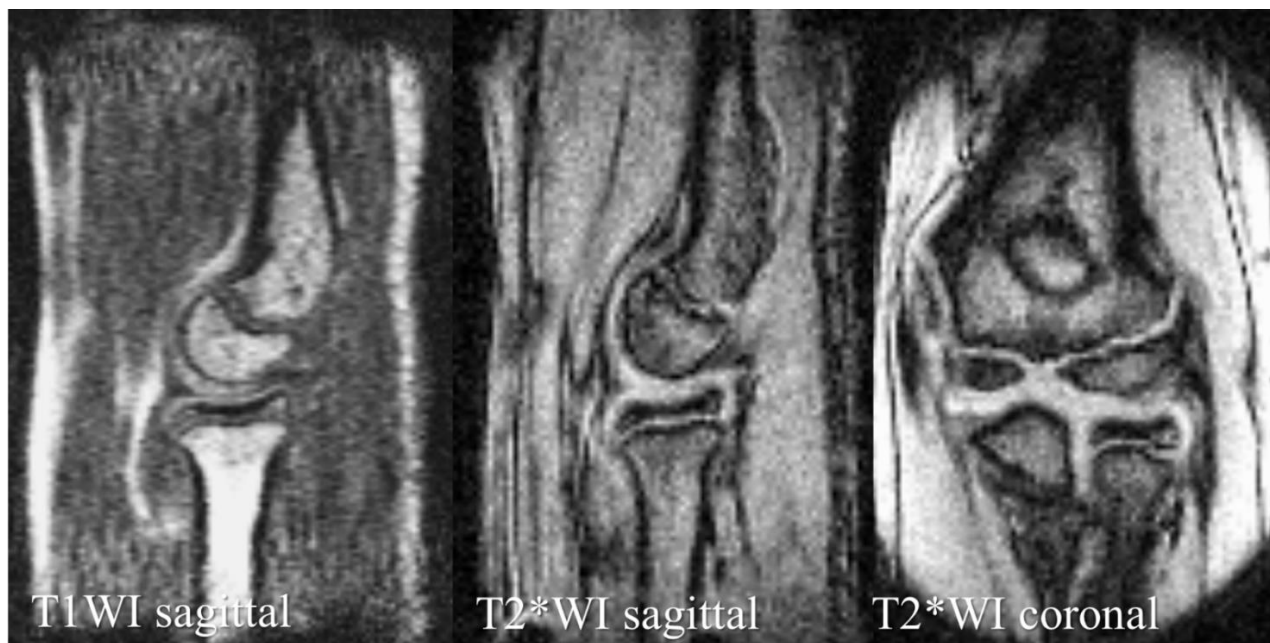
Mobile MRI of a healthy elbow of a 12-year-old boy.
